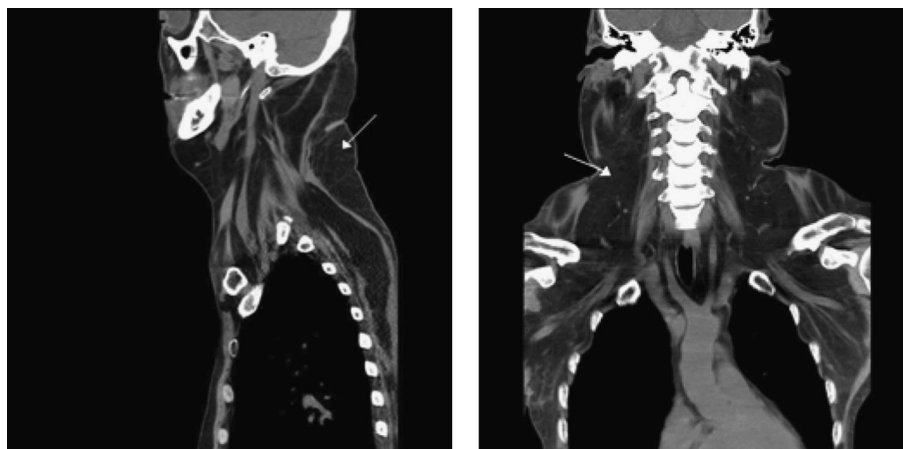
Neck MRI showing fat tissue distribution around the cervical and thoracic spine and shoulder inside the muscular and vascular planes (arrows).
